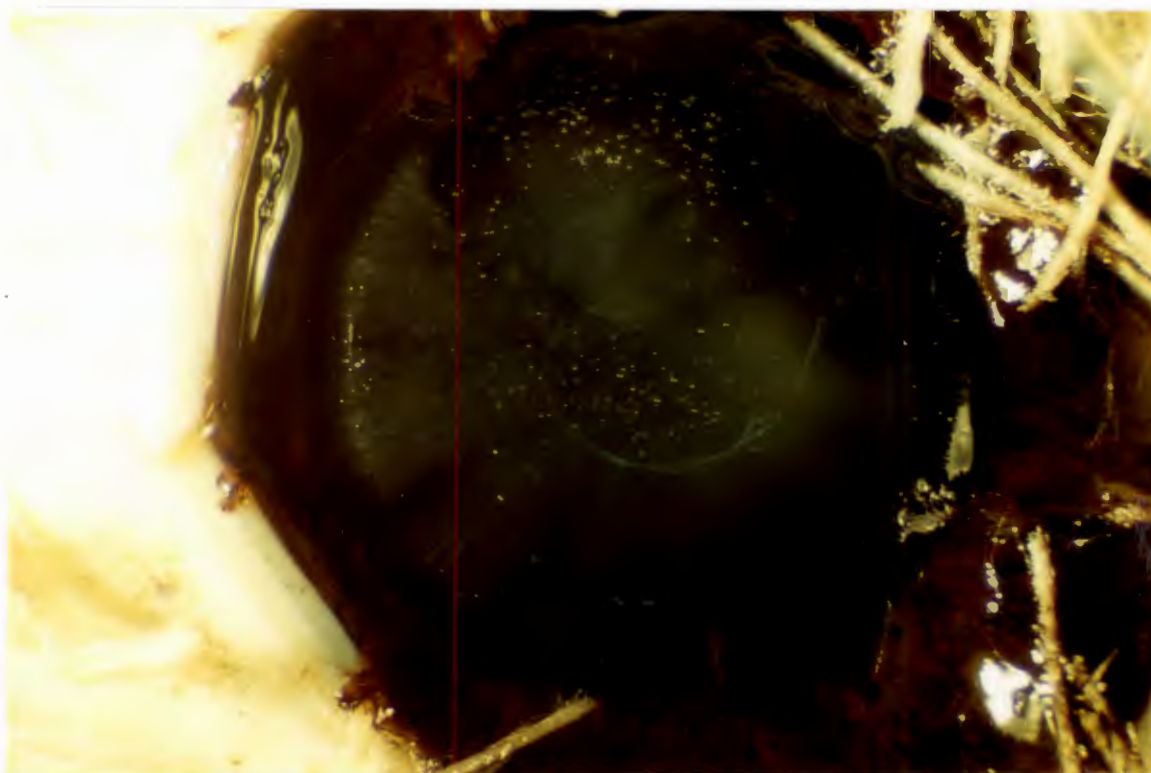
HUMAN LENS AFTER ONE SECOND OF ULTRASONIC EXPOSURE AT 81.6 KHZ*
